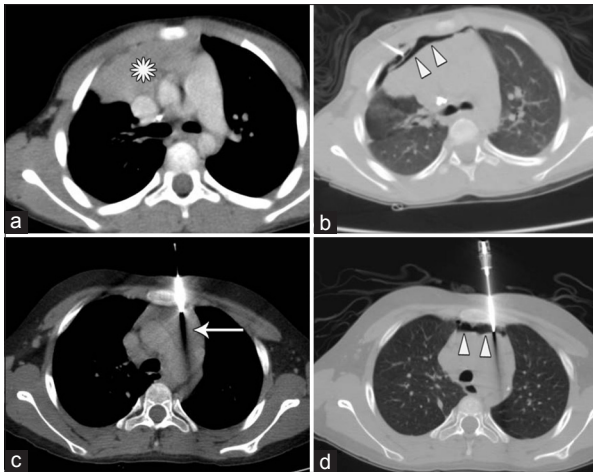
(a) Axial contrast-enhanced computed tomography image of a 6-year-old boy showing suspicious anterior mediastinal lesion (asterisk). (b) Pneumomediastinum resulting in movement of lesion (arrowheads) away from outer cannula. (c) Axial contrast-enhanced computed tomography image showing outer cannula placed at the edge of prevascular node (arrow) in an 11-year-old boy. (d) Movement of lymph node (arrowheads) away from outer cannula due to pneumomediastinum
